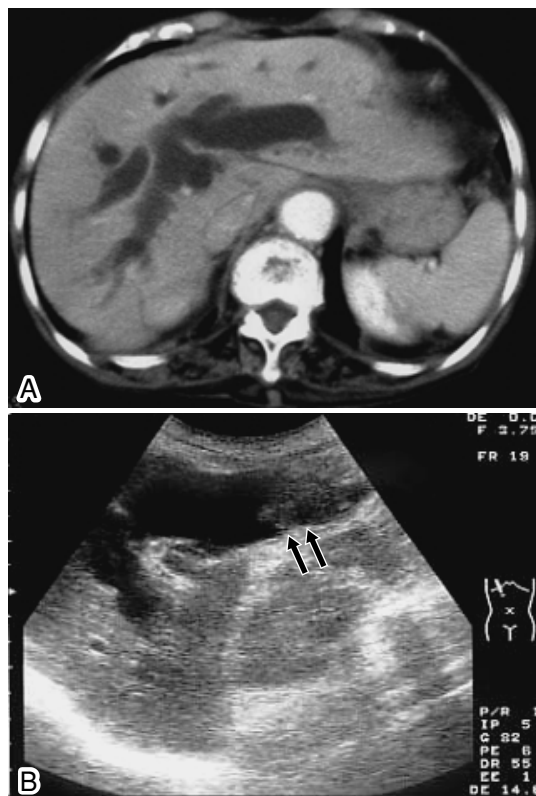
On admission, computed tomography (A) and ultrasonography (B) demonstrate dilatation of the intrahepatic bile duct and common bile duct mass (black arrow).
